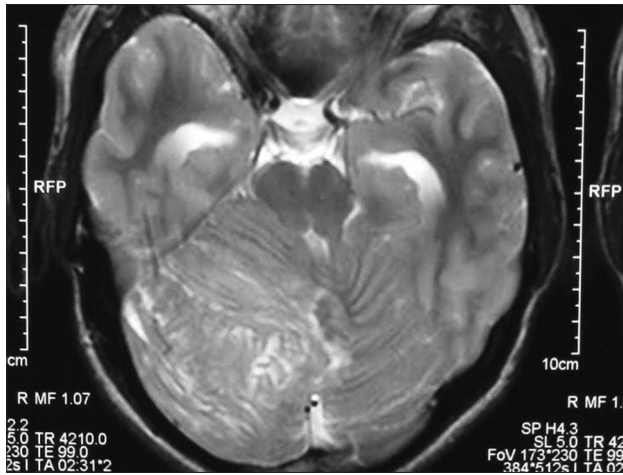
Magnetic resonance imaging (T2-weighted axial) showing typical 'tiger stripe' pattern of cerebellar folia in Lhermitte-Duclos disease
